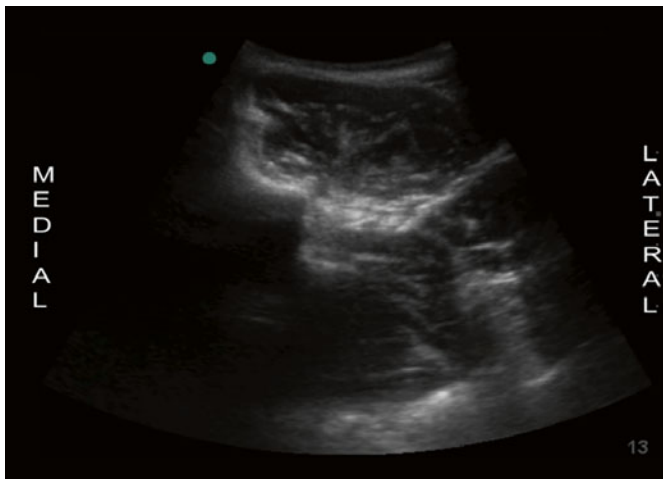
Paramedian ultrasound visualization of the lumbar plexus (Image courtesy of Fernando Mauad, MD and modified by Charles Oliveira, MD)
